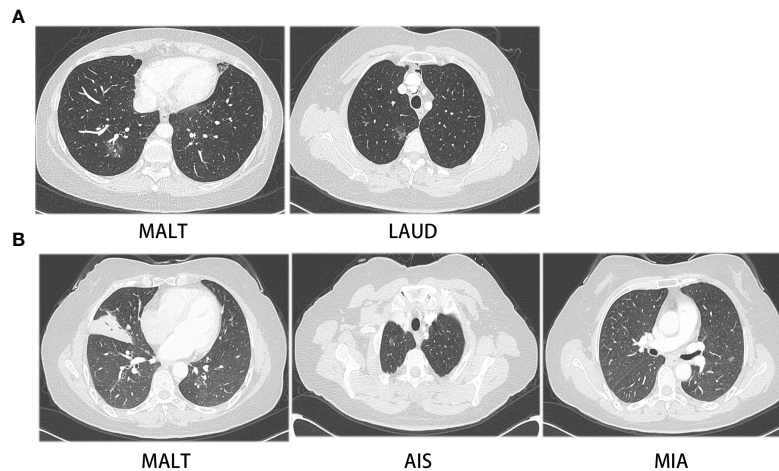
CT images of two patients with synchronous PPL and NSCLC. (A) CT images of patient with MALT and LAUD, (B) CT images of patient with MALT, AIS and MIA.
